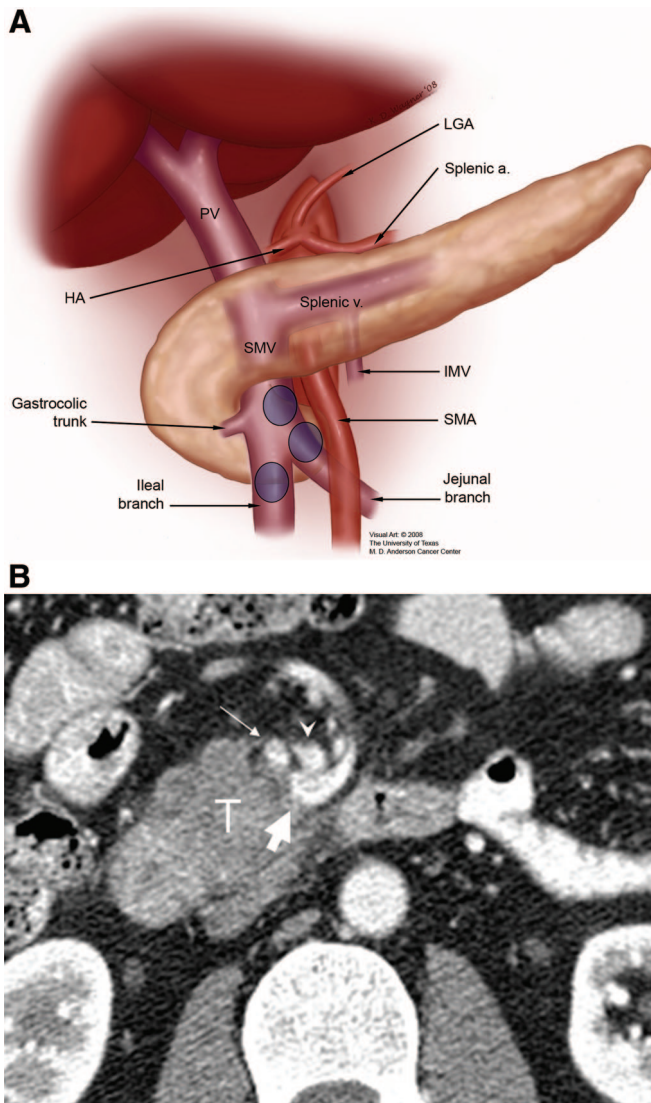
Anatomy of the infrapancreatic superior mesenteric vein (SMV). A, Tumors adjacent to the infrapancreatic SMV may involve either the main SMV trunk or either of its 2 first-order branches (blue circles). The jejunal branch of the SMV is depicted in its typical location running posterior to the superior mesenteric artery (SMA) to drain into the SMV (PV indicates portal vein; HA, hepatic artery; LGA, left gastric artery; IMV, inferior mesenteric vein). B, CT scan of a 48-year-old man with a mixed adeno/neuroendocrine carcinoma of the pancreatic head. The 4.5-cm tumor involved both the distal common trunk of the SMV and the jejunal branch. Pancreaticoduodenectomy required ligation of the jejunal branch (proximal to the tumor in the mesenteric root) and segmental resection of the ileal branch-common trunk of the SMV with interposition grafting as depicted in Figure 3C (T indicates tumor; thin arrow, ileal branch of SMV; thick arrow, jejunal branch of SMV; arrowhead, SMA).
